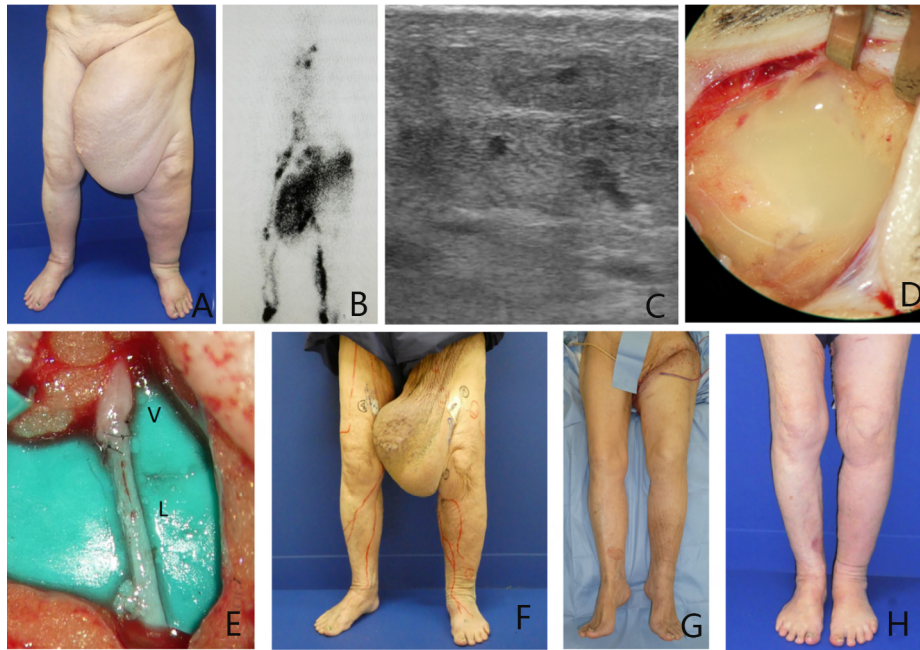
Case 2. A 92-year-old woman with primary lymphedema in the left leg and chylous pleural effusion. (A) Clinical picture at the first consultation. Severe edema can be observed in the left leg, especially in the thigh; (B) Lymphoscintigram; (C) Lymphatic ultrasonographic finding in the left thigh; (D) Intraoperative finding during lymphaticovenous anastomosis (LVA) in the left thigh. Milky discharge, which seems to be a reflux from the intestinal lymph, is observed; (E) Intraoperative finding during LVA. V indicates a vein and L indicates a lymphatic vessel; (F) Clinical picture after LVA and compression therapy. Edema in the left lower extremity has improved; (G) Findings immediately after excision of excess skin and adipose tissue in the left thigh; (H) Clinical picture a few months after the surgery. (A,F,G^[52]).
